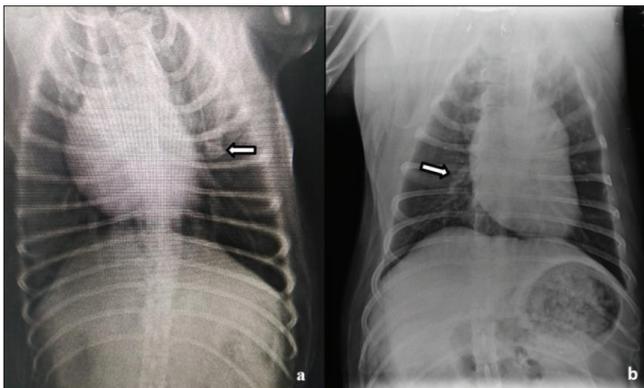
Ventrodorsal radiographic views of the thorax in a 5 years old Terrier (a) and in an 8 years old Cane Corso (b) with MMTs
